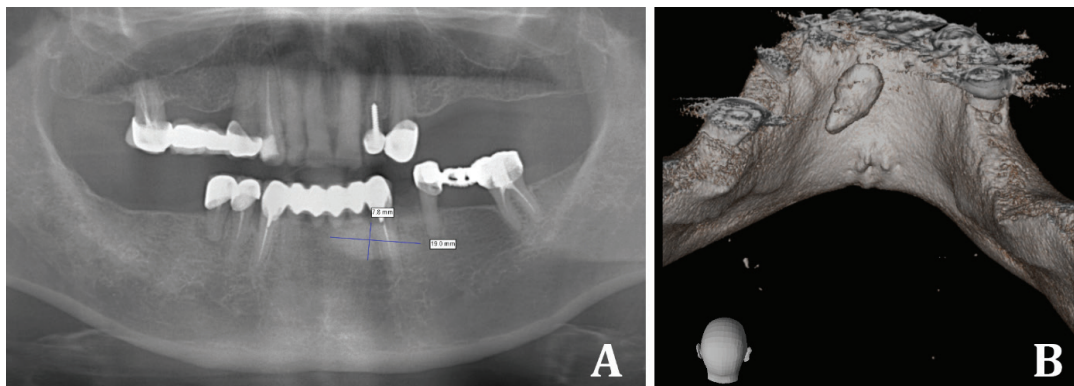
Image of the lesion on the (A) OPG and (B) a three-dimensional model created using CBCT.
